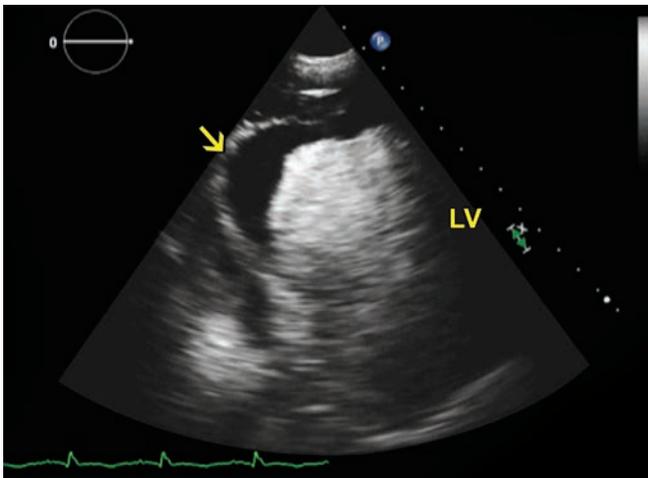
Transthoracic echocardiogram in off axis 2 chamber view with ultrasound contrast agent showing large aneurysm/pseudoaneurysm with associated thrombus (arrow).
